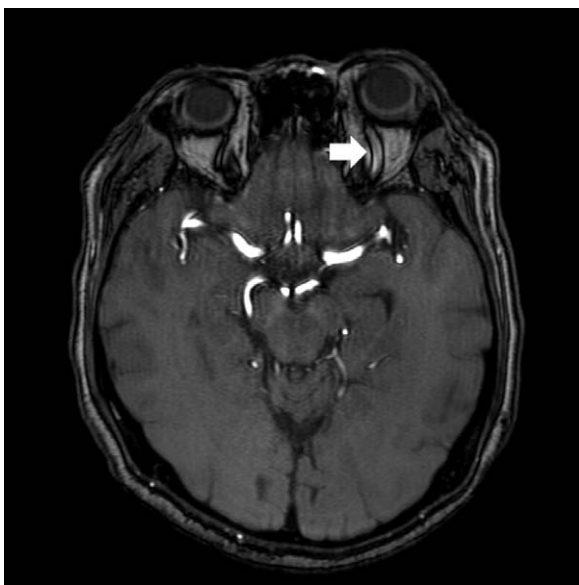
Time-of-flight magnetic resonance imaging of the patient showed mild exophthalmos and dilated superior ophthalmic vein (arrow) of left eye.
